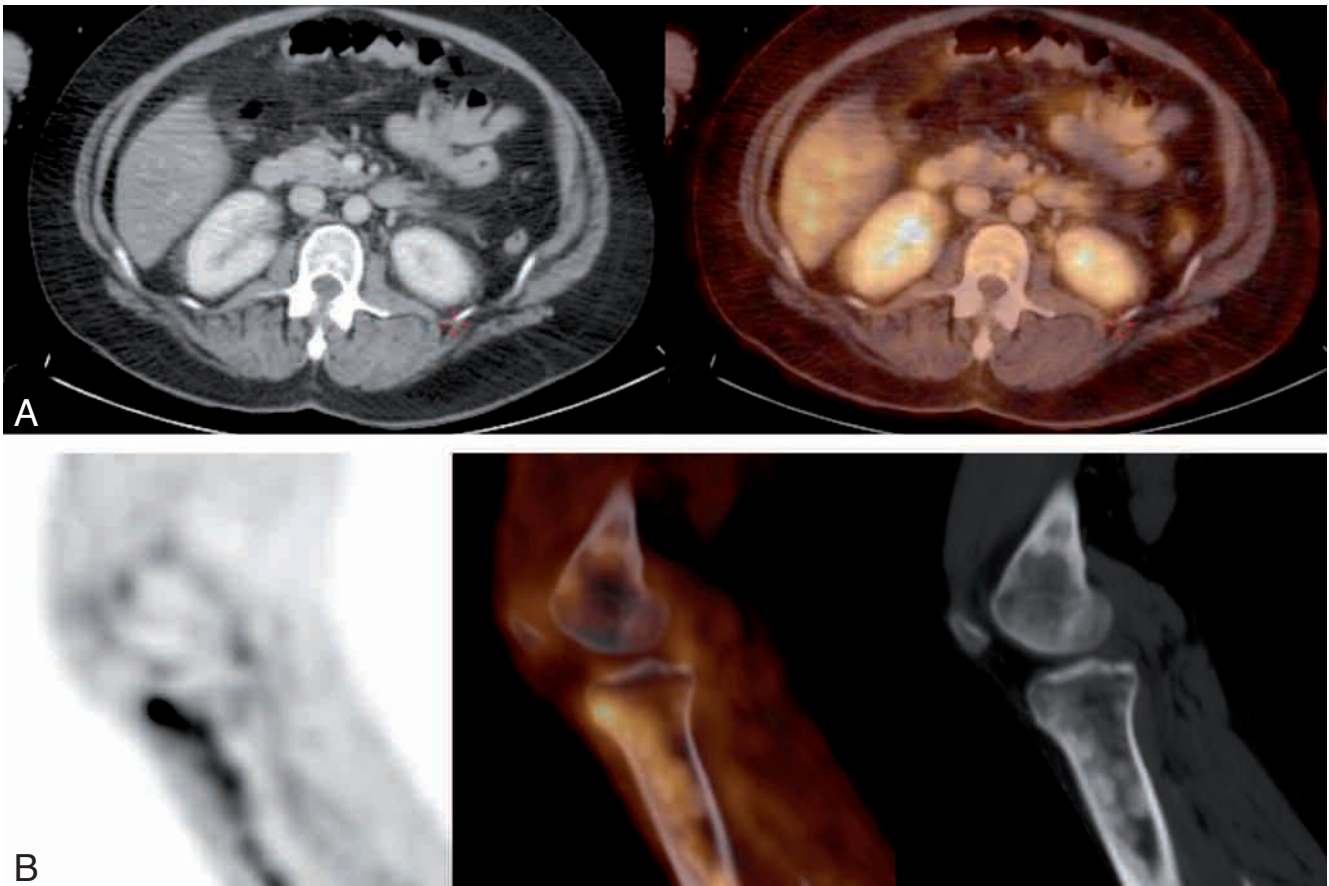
A. <sup>18</sup>F FDG PET/CT revealed metabolic active perinephric stranding, an atypical sign of retroperitoneal fibrosis. B. All visceral and skeletal lesions were hypermetabolic.
